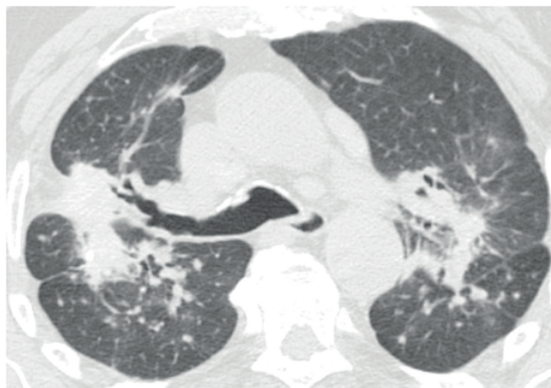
HRCT scan showing heterogeneous conglomerate masses in the upper lobes bilaterally, containing areas of architectural distortion and small adjacent nodules.
